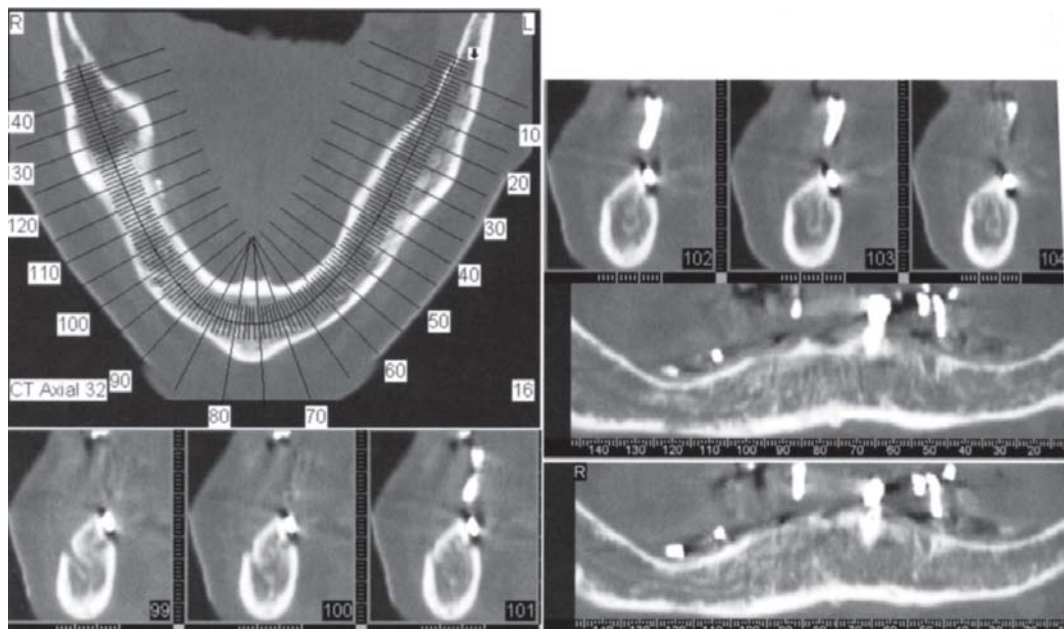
Programmed Dental CT. The radiologist identifies curvature of the mandible, which programs the CT work station to create reformed cross-sectional and curved plane images. Axial view of mandibular alveolus with curvature of the mandible defined and location of the derived cross-sectional and curved plane images identified. Images 99 to 102 are cross-sectional images and that are referred to as axial and curved plane images. Images 8 and 9 are curved plane images that are referred to as the axial and cross-sectional images. Gutta percha radiopaque cylinders identify prospective implant positions
